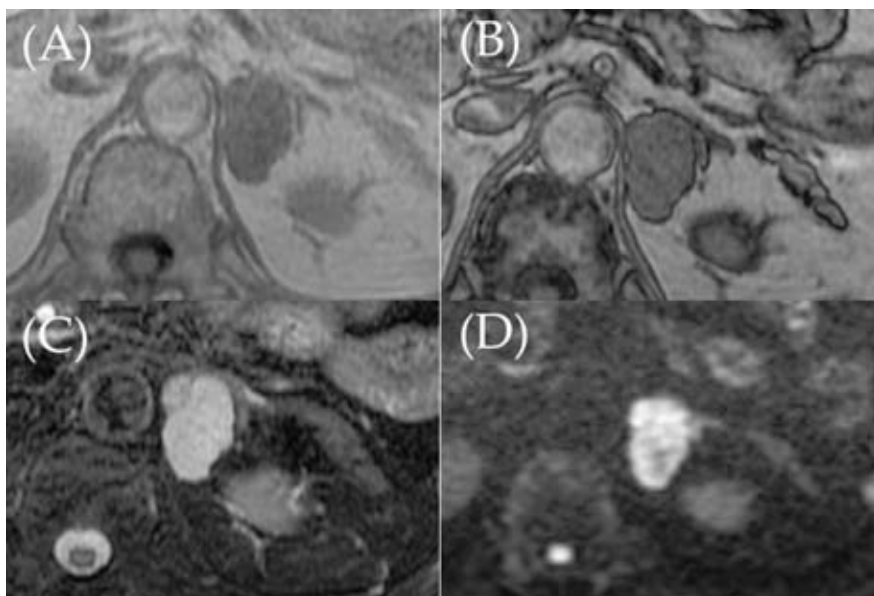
Magnetic resonance images showing an adrenocortical neoplasm exhibiting no loss of signal intensity on out-of-phase imagery. The neoplasm showed high signal intensity on T2-weighted and DWI images. A) Axial in-phase; B) out-of-phase; C) T2-weighted; D) DWI.
